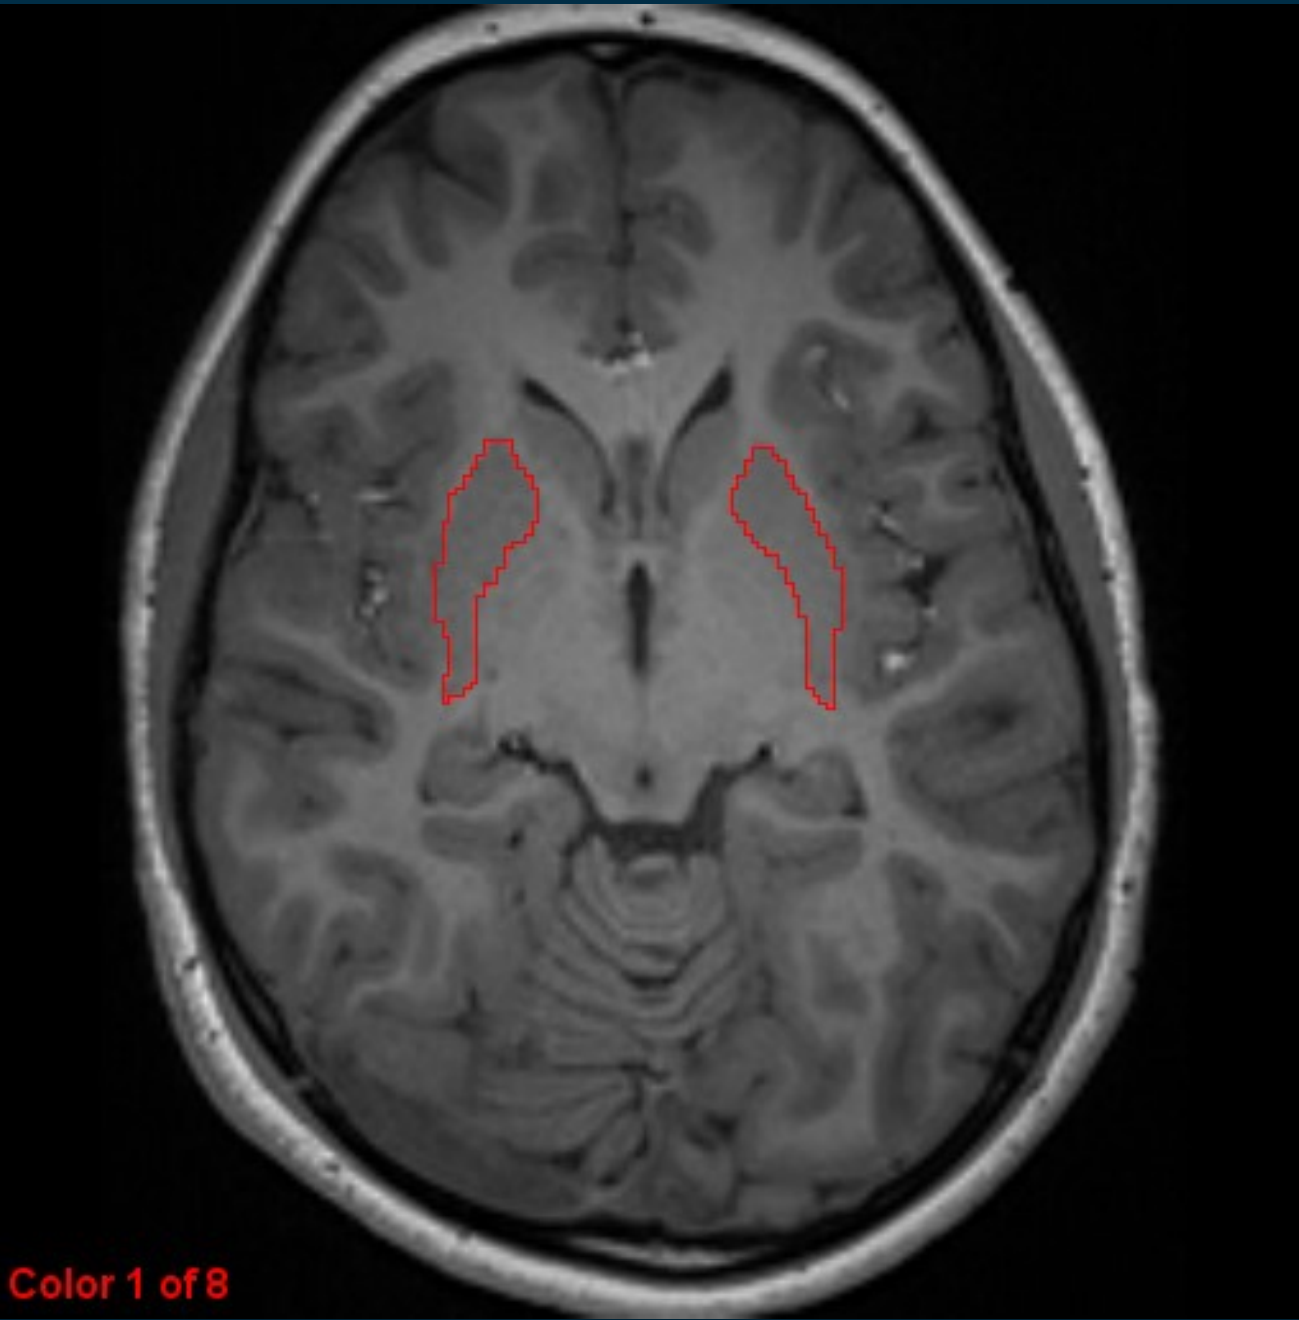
High-resolution T1-weighted MRI transverse image showing the region of interest. The putamen is outlined in red.
